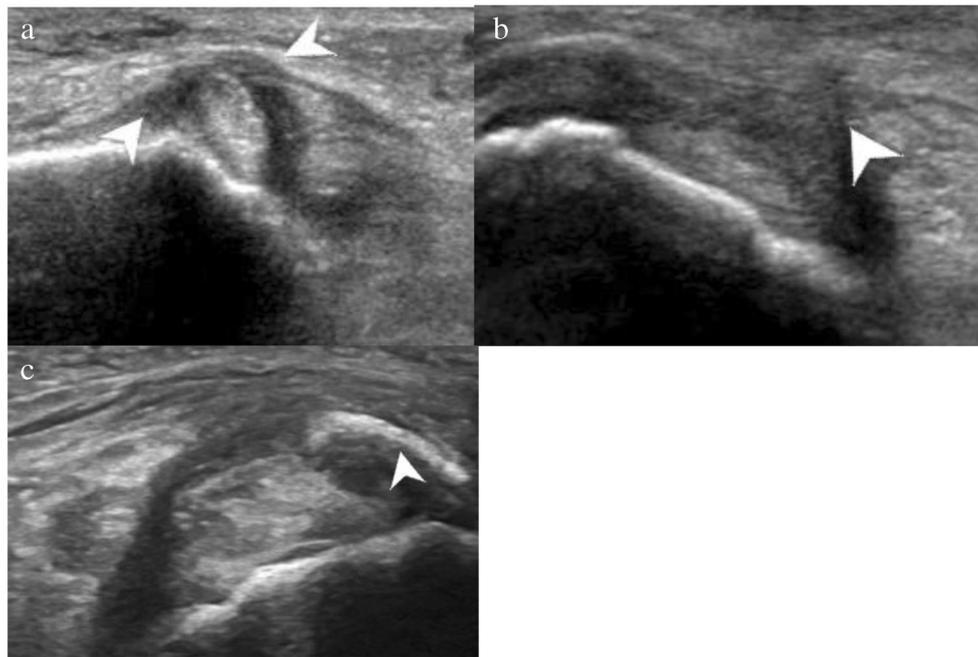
Ultrasound images of subluxation of the PTT and associated abnormalities related to the flexor retinaculum. a Short-axis ultrasound image of a 28-year-old female athlete with a history of a previous ankle injury and instability demonstrates mild anterior subluxation of the PTT at the medial malleolus. Flexor retinaculum (*arrowheads*) is slightly thickened and irregular, but intact. b Short-axis ultrasound image at the level of the distal medial tibia of a 43-year-old man with a history of ankle trauma
